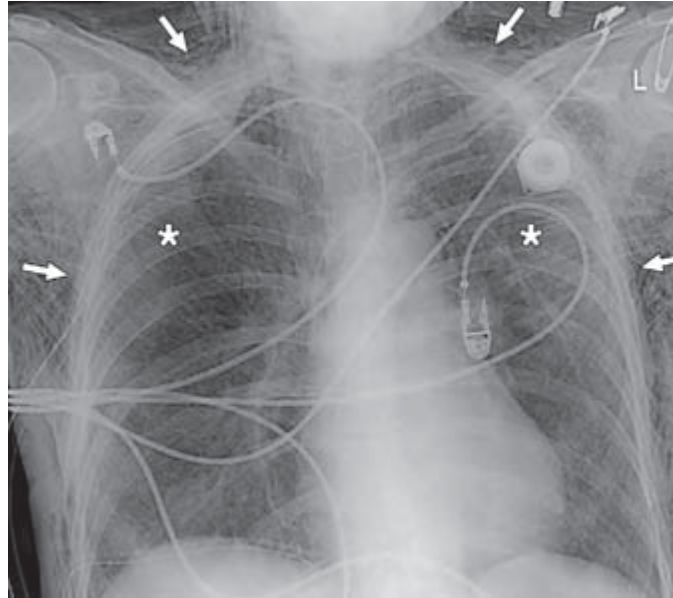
Frontal chest radiograph shows extensive subcutaneous emphysema (arrows) and air outlining fibers of pectoral muscles bilaterally ("ginkgo leaf" sign) (asterisks). (Ho & Gutierrez, 2009).
